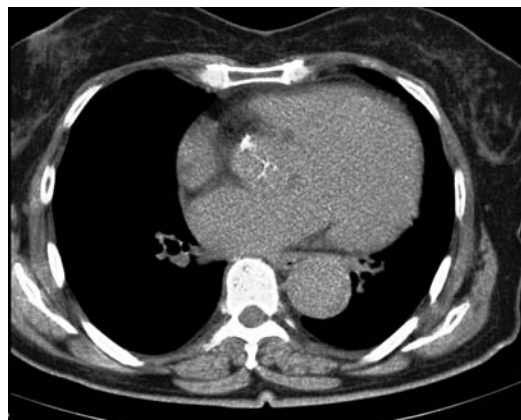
Helical computed tomography of the aortic valve, not cardiac gated, showing typical X-, instead of Y-shaped closure of the aortic valve.
